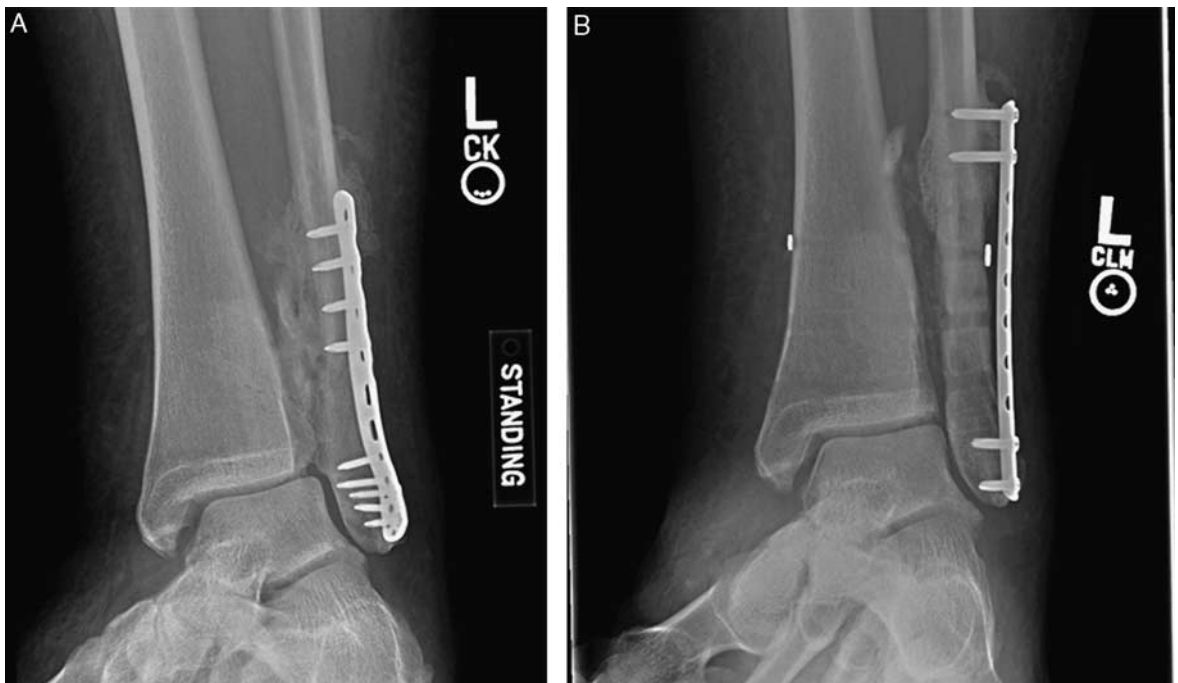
A, Preoperative mortise of a patient with an untreated syndesmotom injury who developed a significant synostosis. B, Three-month postoperative radiograph demonstrates excision of the synostosis with stable reduction of the syndesmotom and medial clear space.
